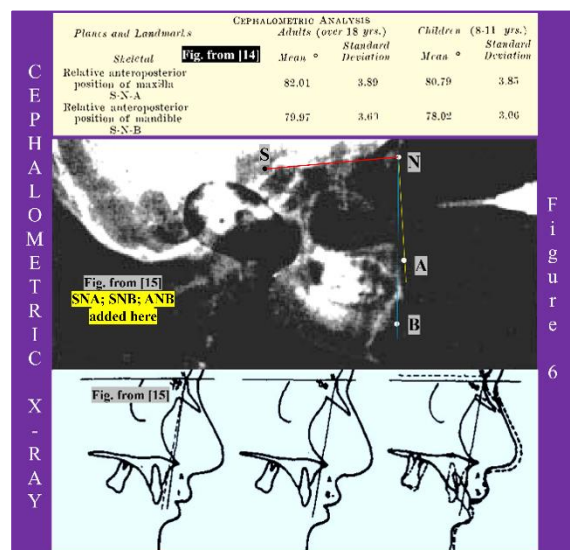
The cephalometric radiographs
